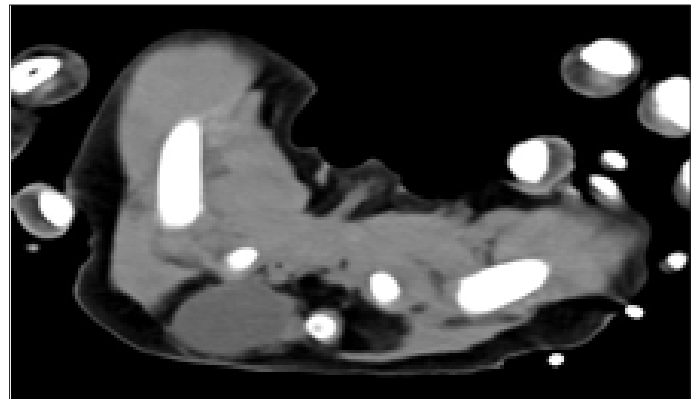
Sacrococcygeal teratoma Computed Tomography Image
